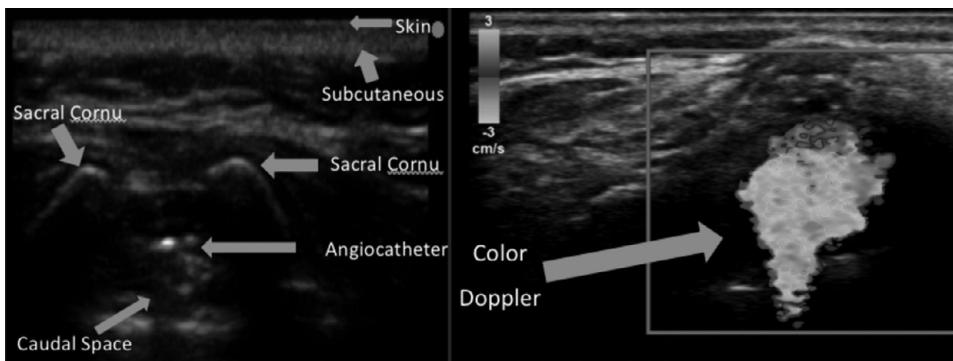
Left: Ultrasound guidance for visualization of caudal block placement. Right: Use of Doppler ultrasound to identify location of injection. Courtesy of Adam C. Adler, MD
